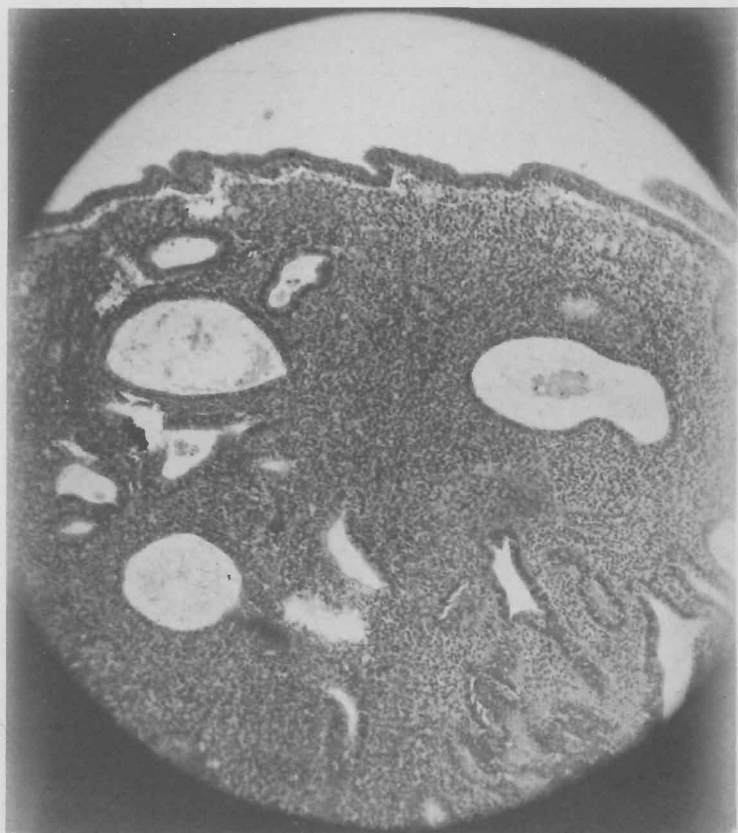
Case 8. W. U. Secondary amenorrhea (x-ray castration). Experimental production of cystic and glandular hyperplasia of the endometrium. 700,000 R.U. of progynon-B given.
